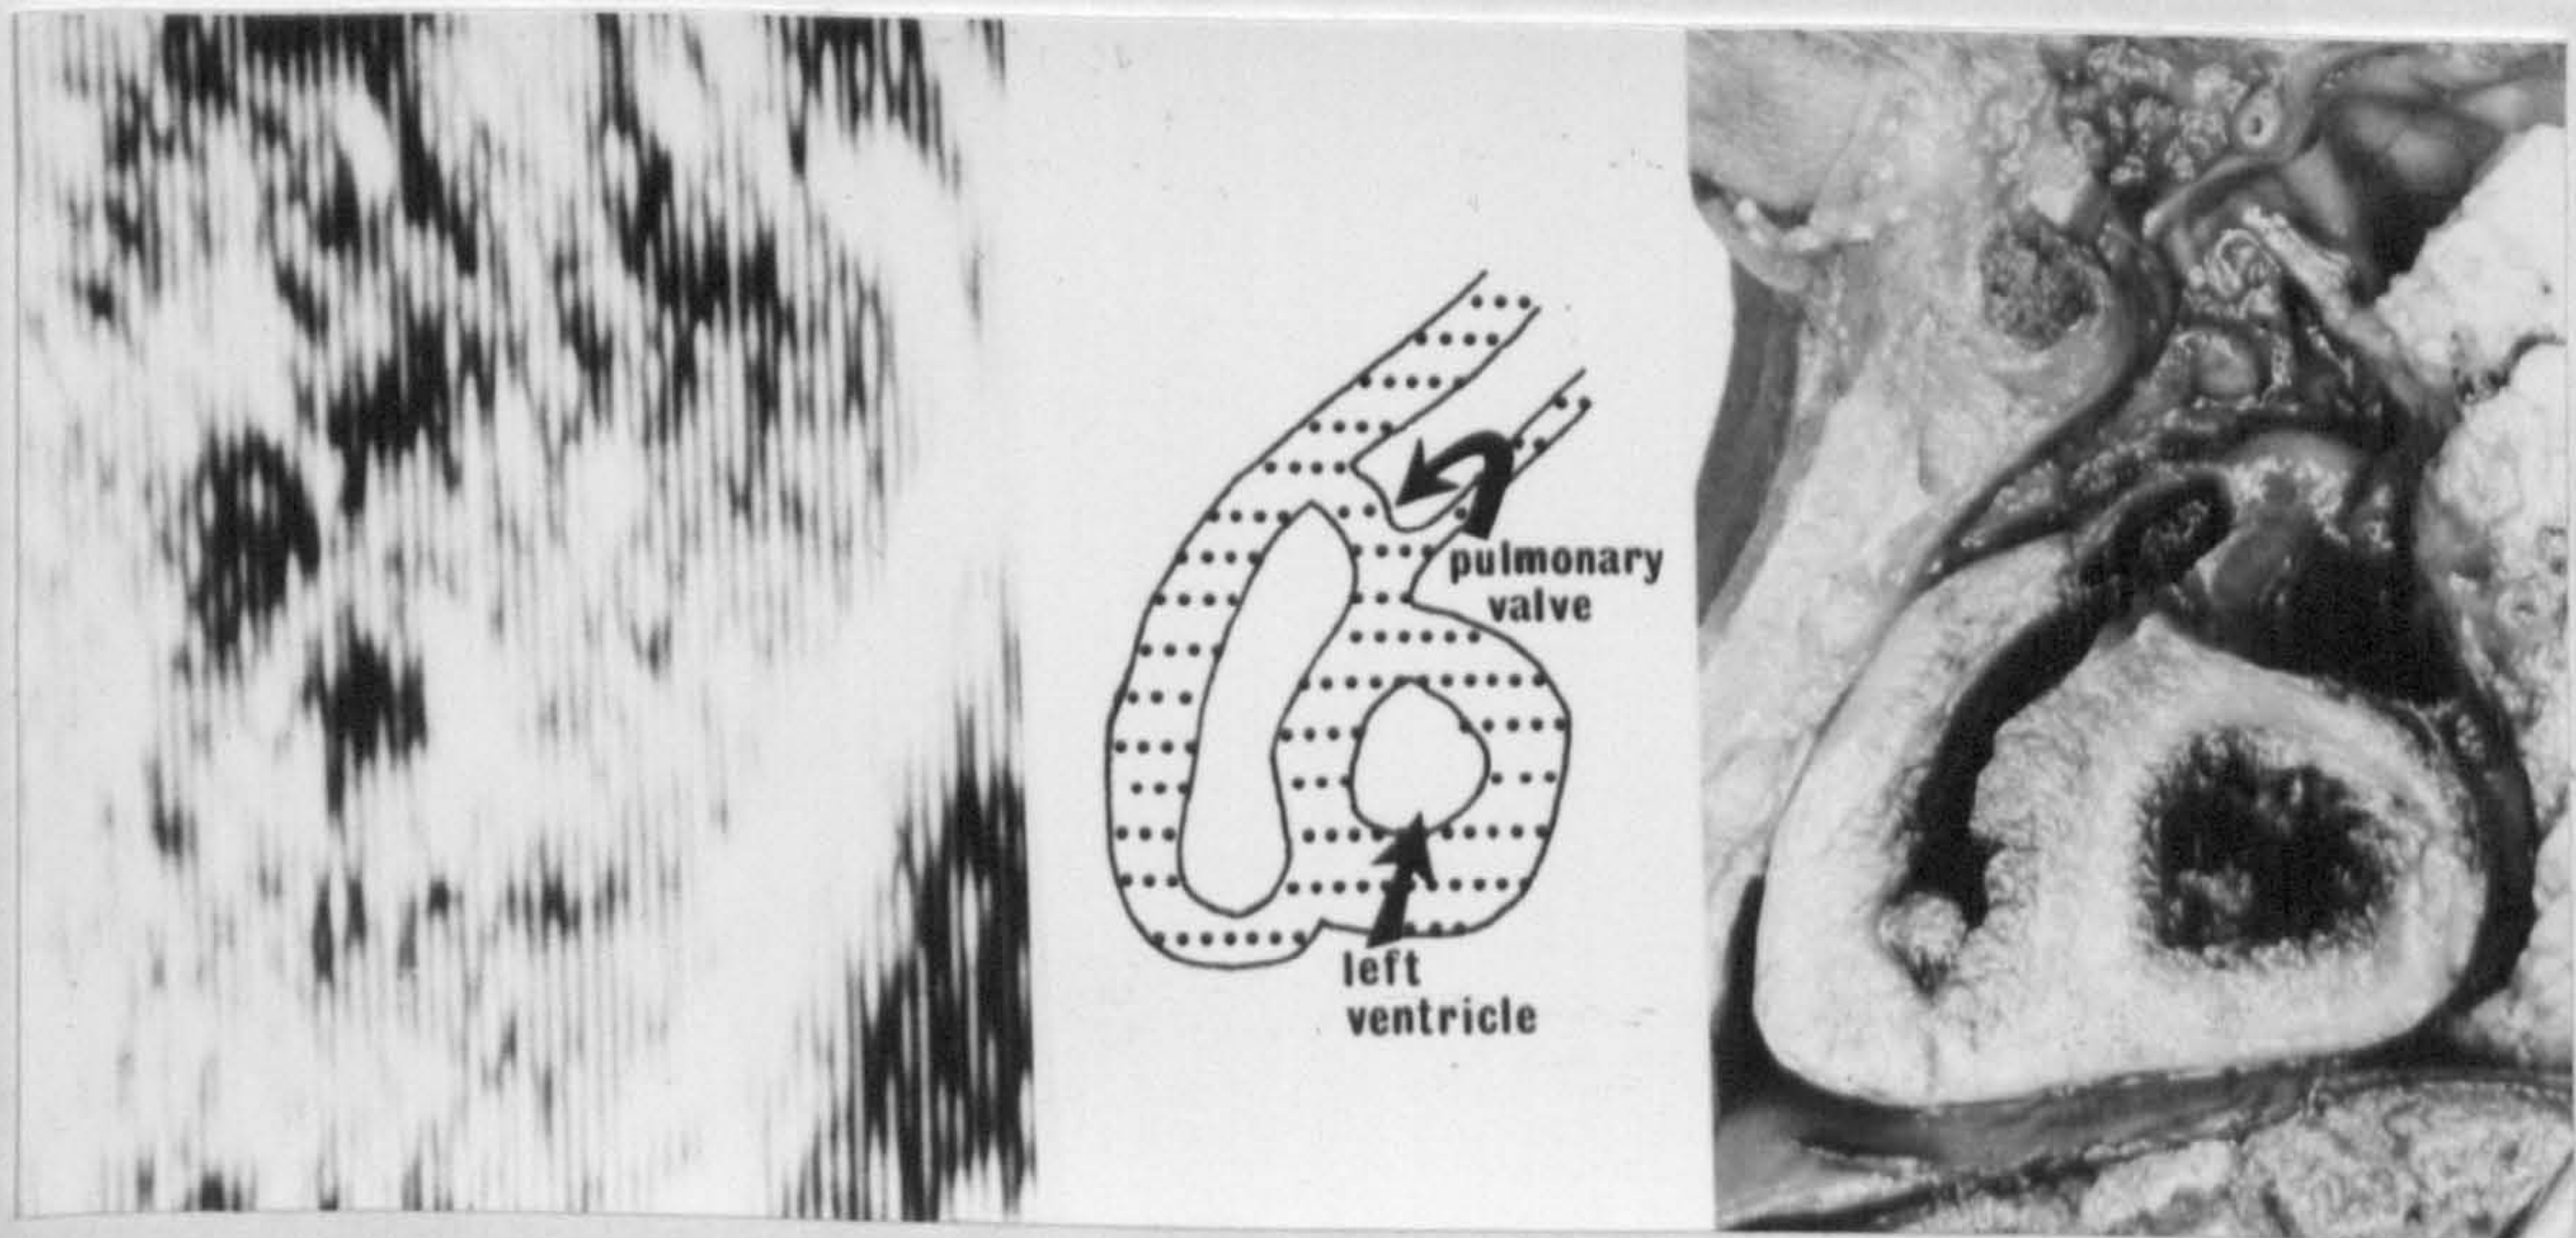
Short axis left ventricular plane displayed echocardiographically and anatomically. The left ventricle is seen as a concentric structure with the pulmonary outflow tract and complete muscular infundibulum which supports the pulmonary valve, arching over it.
